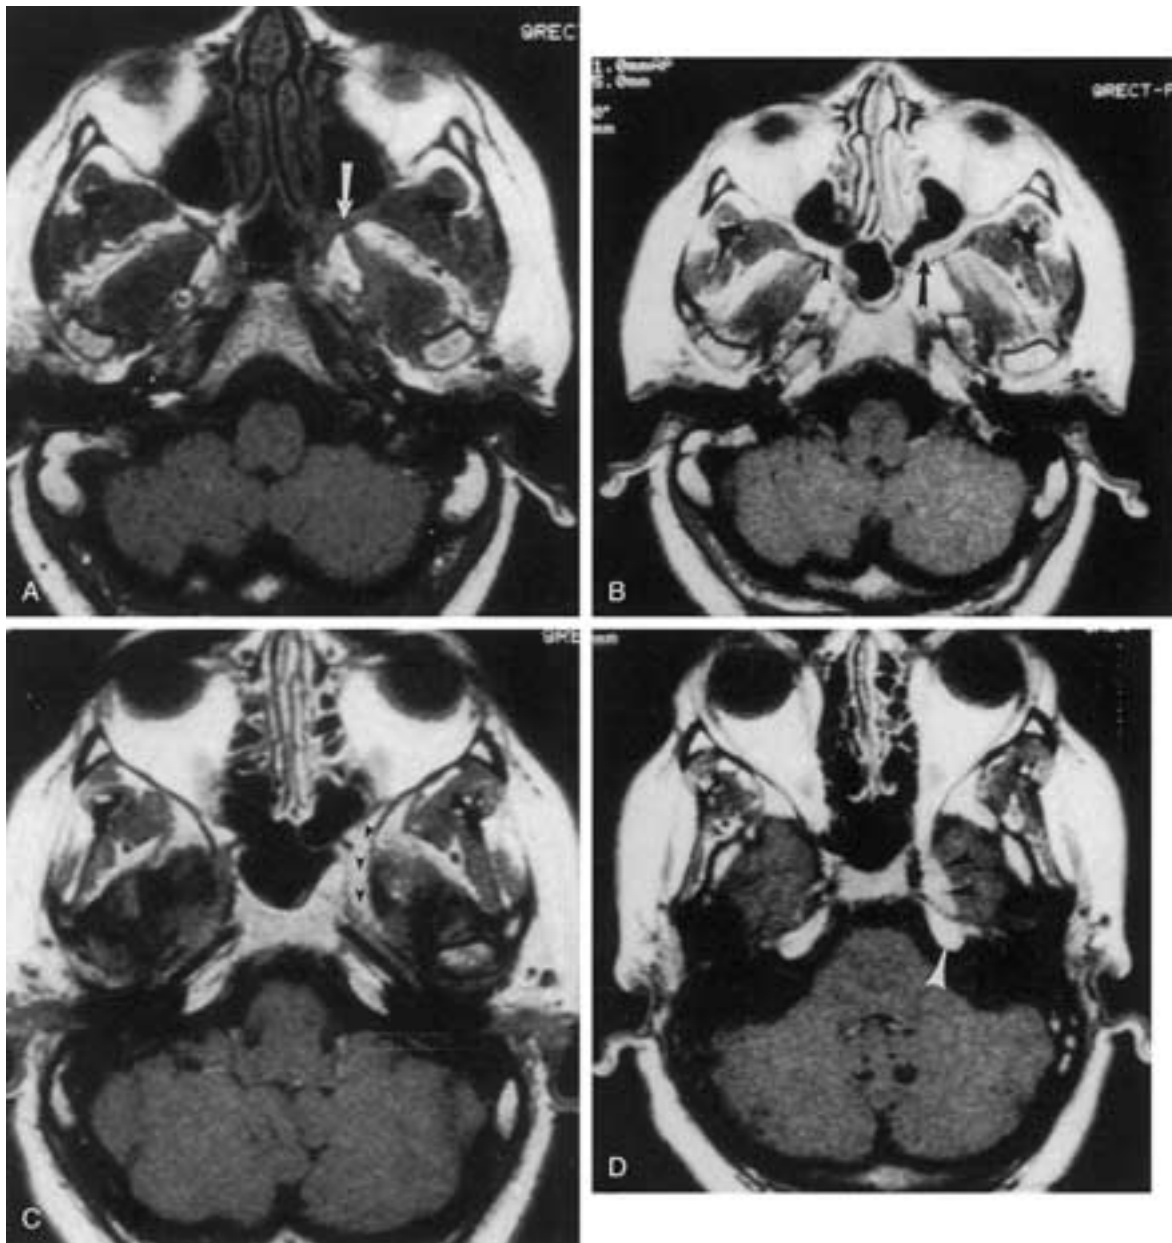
Adenoid cystic carcinoma of the palate extending along the branches of V₂. A, Axial T1-weighted image through the pterygopalatine fossa shows obliteration (*white arrow*) of the fat within the pterygopalatine fossa. Compare this with the normal fossa on the opposite side. Fat normally should be identified in this narrow structure. B, Postgadolinium T1-weighted image. Now the tumor enhances (*black arrow*). Without fat suppression (compare with the noncontrast study), this appearance might be considered normal. Compare it with the high signal of the fat in the normal pterygopalatine fossa on the opposite side. C, Postgadolinium T1-weighted image (slightly higher) shows enhancement of the tumor within the foramen rotundum (*black arrowheads*) leading toward Meckel's cave. D, Slightly higher postcontrast enhancement T1-weighted image shows the enhancement in the lower cavernous sinus (*black arrowheads*) obscuring Meckel's cave. The high signal of the fat in the petrous apex (*white arrowhead*) should not be confused with tumor.
